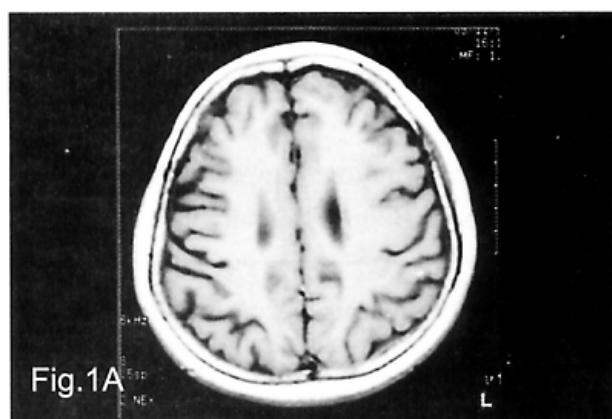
MRI showing asymmetrical cortical atrophy, mainly in the right parietal and frontal lobes (A, B). HMPAO-SPECT showing marked hypoperfusion in the right parietal lobe (C) and right basal ganglion and mild in the bifrontal areas (D).
